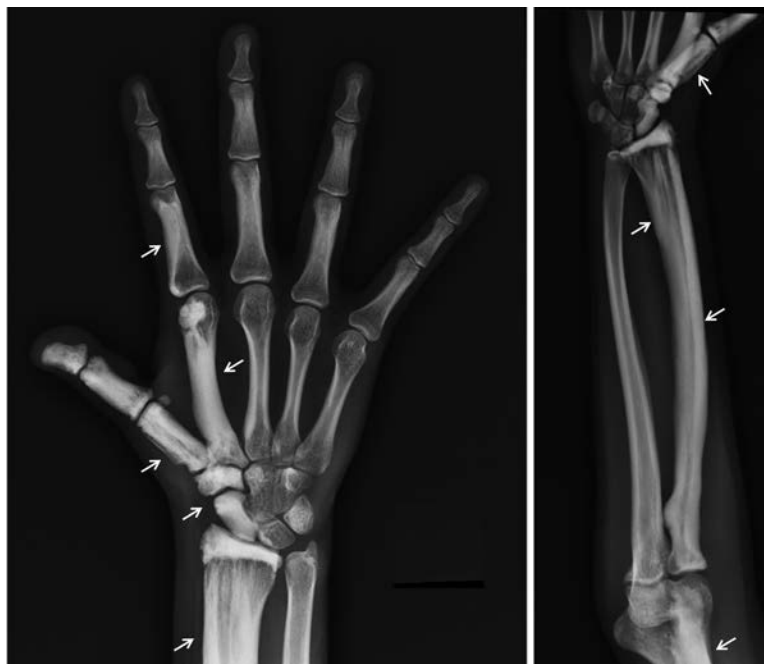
Radiography of the right upper limb showing extensive osteoma-like lesions. Arrows indicate the main areas of melorheostosis.
